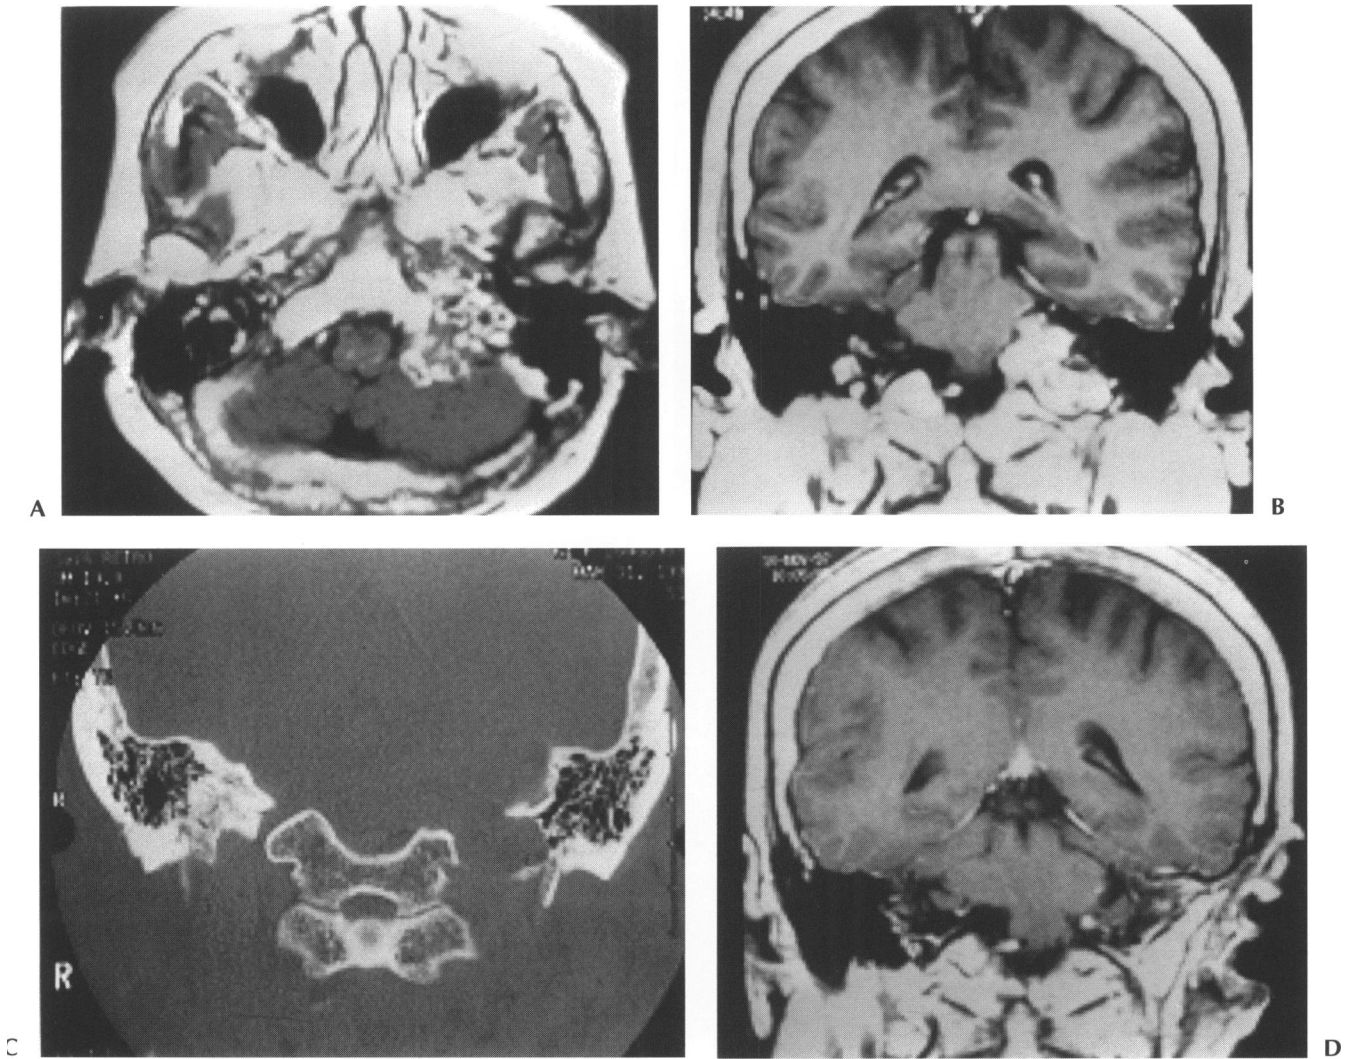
Type A tumor (case 1). (A) Axial enhanced CT showing right cerebellopontine angle mass with central lucency. The tumor mass showed poor contrast enhancement, and enlargement of the internal acoustic canal was not observed. (B) Coronal enhanced CT showing posterior fossa mass. Enlargement of the right jugular foramen, relative to that on the left, was not noted. (C) Bone algorithm coronal CT showed normal jugular foramen. (D) Coronal gadolinium-enhanced T1-weighted MRI showing tumor mass with strong enhancement. Slight extension of the tumor into the right jugular foramen was observed. (E) Postoperative coronal gadolinium-enhanced image showed no residual tumor.
